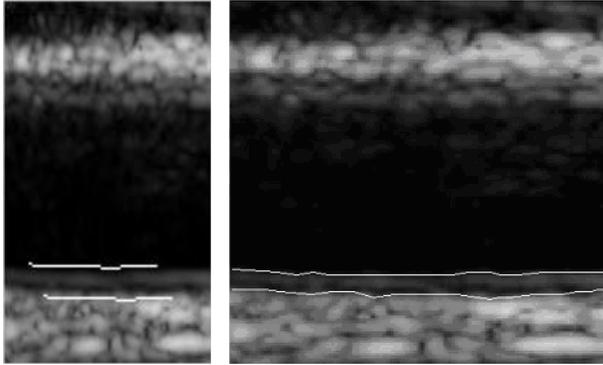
Longitudinal Ultrasound Images of the CCA.
